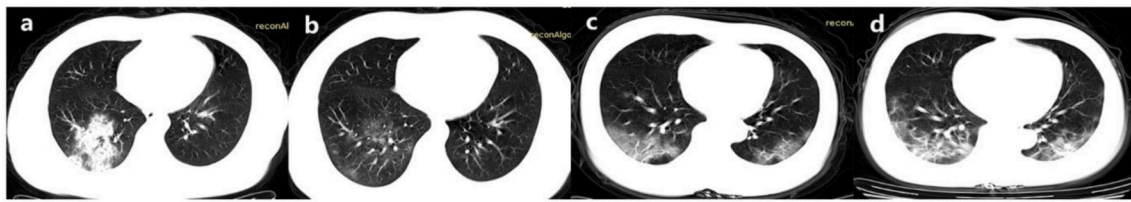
Radiographic comparison between the first and second CT scan 3 days later. 2a-b. Decreased area and density of GGO. 2c-d. Increased area and density of GGO.
